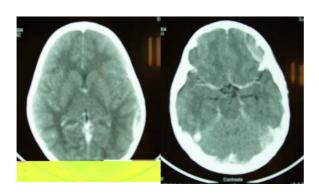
= CT scan, Sept 14, 2004
